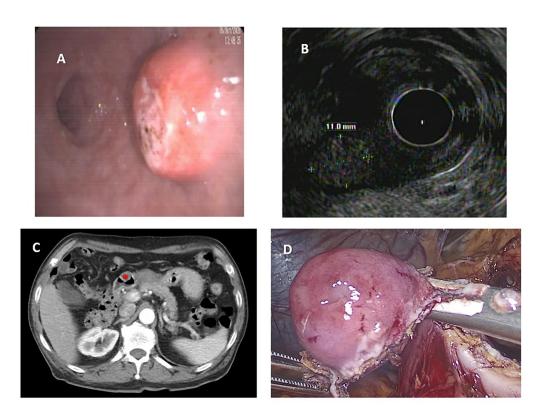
A. Endoscopic vew of duodenal bulb lesion. B. Endoscopic ultrasound image of the lesion C. CT scan (*) D: Laparoscopic resection of the lesion
